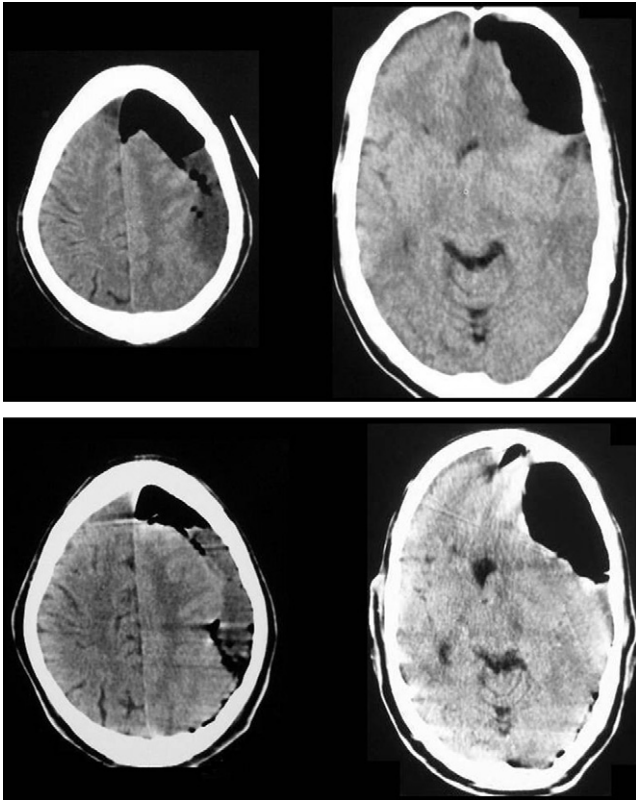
Axial brain CT scans (upper) 3 days prior to admission showing a large air-filled cavity with subdural fluid; and (lower) on admission showing an increase in the amount of air and the mass effect compared to 3 days prior.
